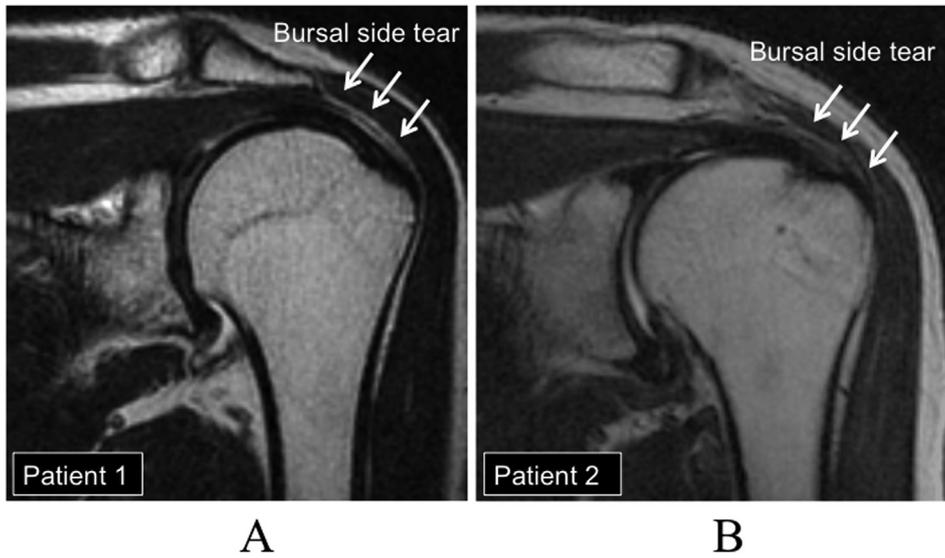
Preoperative coronal T2-weighted MRI of patient 1 (a) and patient 2 (b). White arrows indicate a bursal-side, partial-thickness tear in the supraspinatus tendon.
